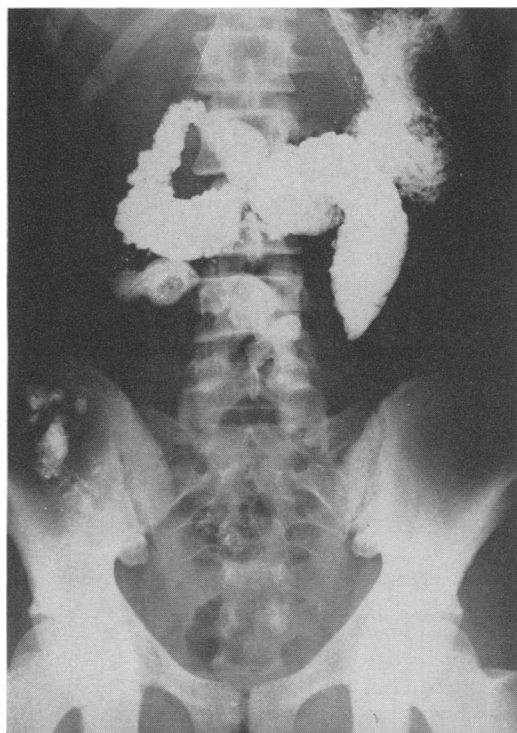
Roentgenogram, A-P view, showing almost complete obstruction of the proximal jejunum. The opaque media seen caudad to the point of obstruction was that used at a previous examination, 72 hours prior to the development of the obstruction seen above.
